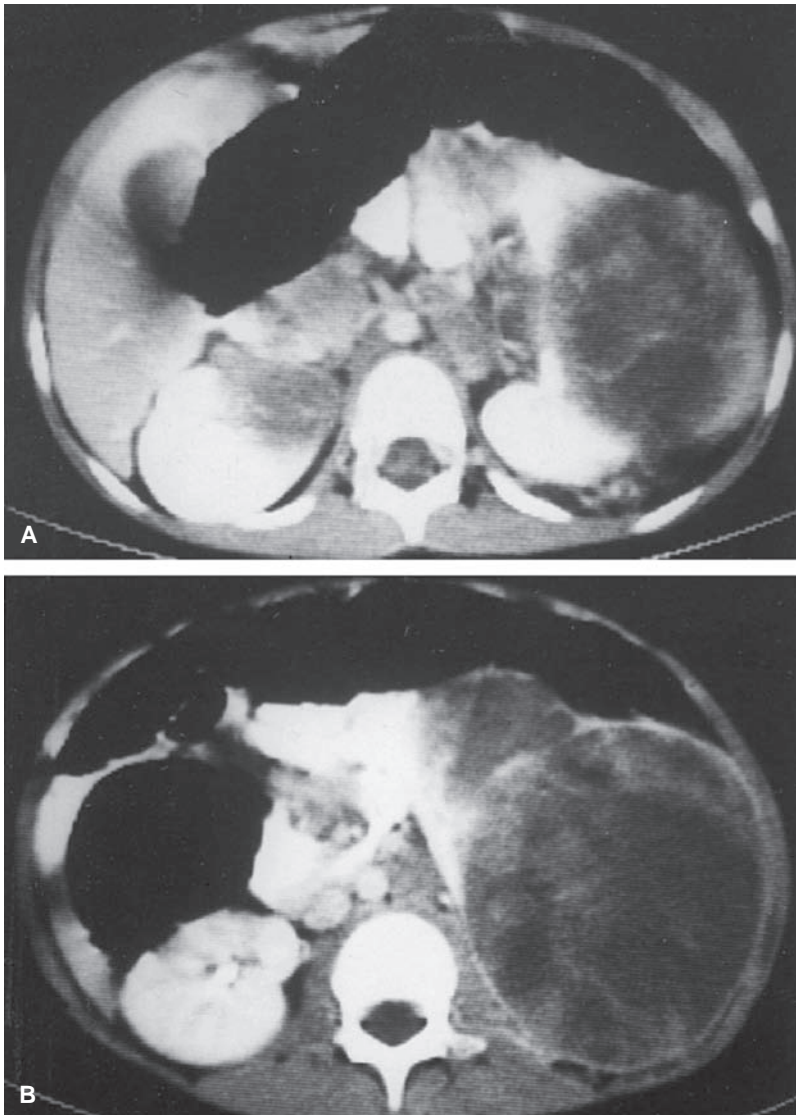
A: Bilateral Wilms' tumor. A 5-year-old girl with left flank mass. CT sections of the upper abdomen with contrast medium enhancement show a necrotic mass arising from superior aspect of the left kidney. Note a small mass in the superior medial aspect of the right kidney. B: Bilateral Wilms' tumor (same patient as in A). CT section of the abdomen with contrast medium enhancement shows extent of the large necrotic left Wilms' tumor with periaortic adenopathy.
